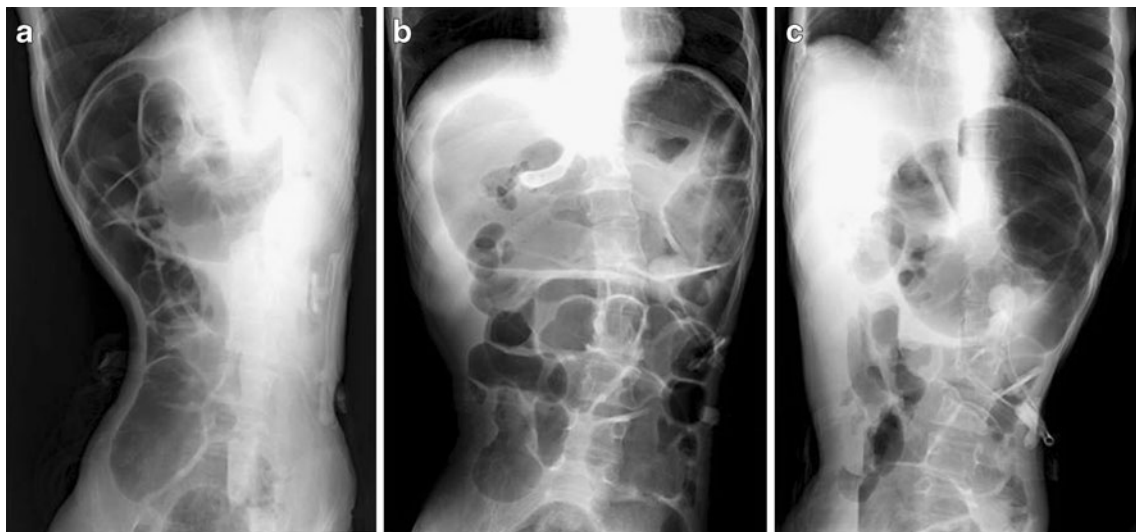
Abdominal radiographs on admission. a Radiograph in the left lateral decubitus position demonstrating the liver located in the left hypochondrium. b Radiograph in the supine position demonstrating
